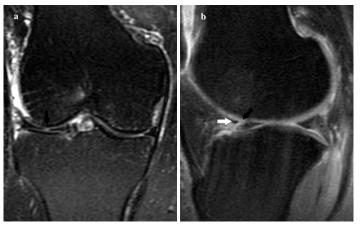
a, b: Coronal T2W Fat Sat 1.5 T MRI image shows a vertical tear in the lateral meniscus anterior horn (arrow, a). Sagittal PDW Fat Sat 1.5 T MRI image demonstrates an oblique tear (black arrow, b) adjacent to the transverse ligament (white arrow, b) in lateral meniscus anterior horn.
